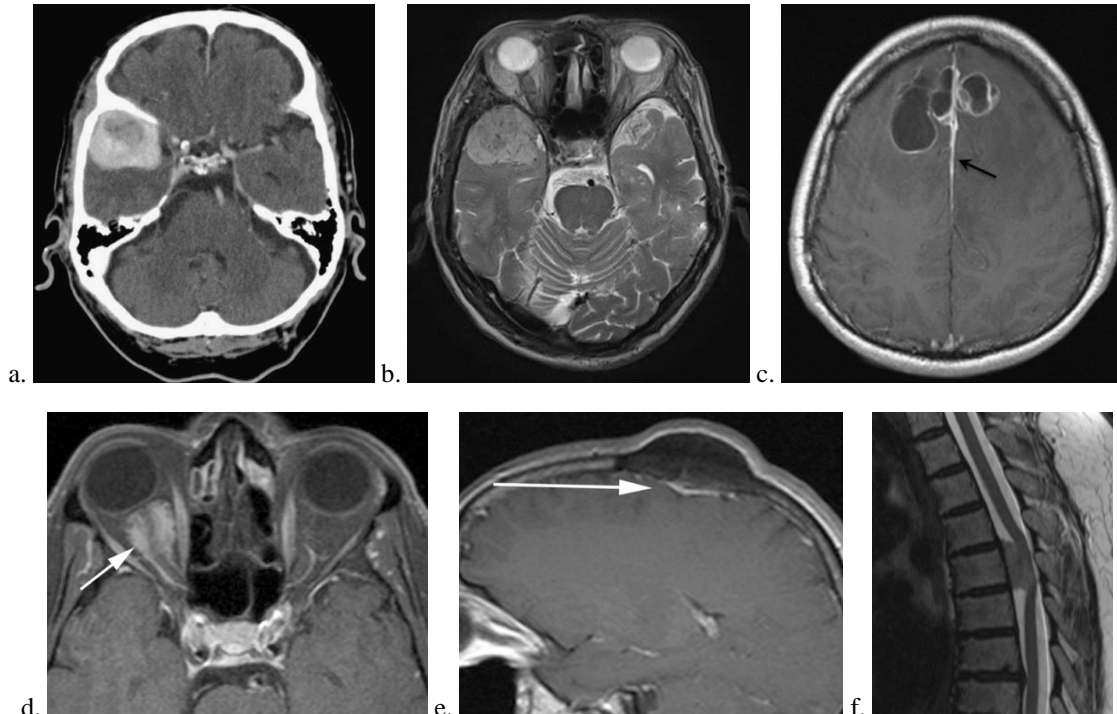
Meningioma imaging with CT scan and MRI. a. sphenoid ridge meningioma on CT scan (axial); b. same lesion on T2 MRI (axial); c. cystic meningioma with dura tail (black arrow) on T1 MRI (axial); d. meningioma surrounding the right optic nerve on T1 MRI (axial) ; e. *en plaque* meningioma with hyperostotic focus on T1 MRI (sagittal); f. spinal cord meningioma at the T5 level narrowing the spinal canal on T2 MRI (sagittal) / (images from^{12,21})
